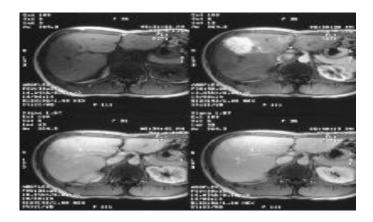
Dynamic MRIs in a 36-year-old woman referred for a gallbladder sonography, during which the patient was found to have a vague ill-defined hypoechoic mass in the right lobe of the liver (not shown). (Top left) Gadolinium-enhanced T1-weighted MRI demonstrates an ill-defined low-signal-intensity mass. (Top right) The mass enhances intensely in the arterial phase after the administration of contrast medium. (Bottom left) Minor enhancement persists in the portal venous phase. (Bottom right) The lesion becomes isointense relative to the liver on delayed images.
